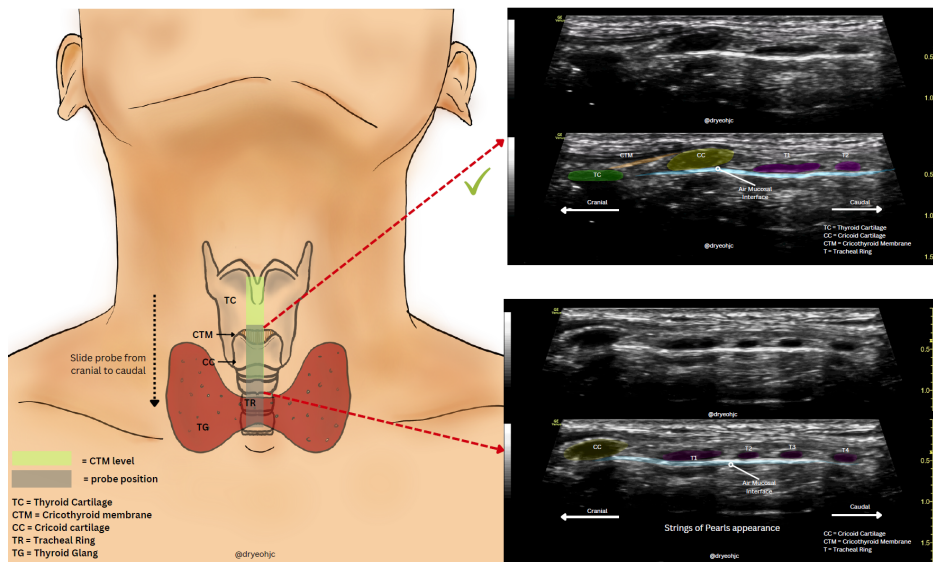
The longitudinal approach of airway ultrasound. The thyroid cartilage, cricothyroid membrane, cricoid cartilage, tracheal rings, and air mucosal interface is visualised in a single view. Tip: Slide the probe left and right to obtain a true midline view, where the air mucosal interface appears as a straight hyperechoic line with its surrounding structures.
